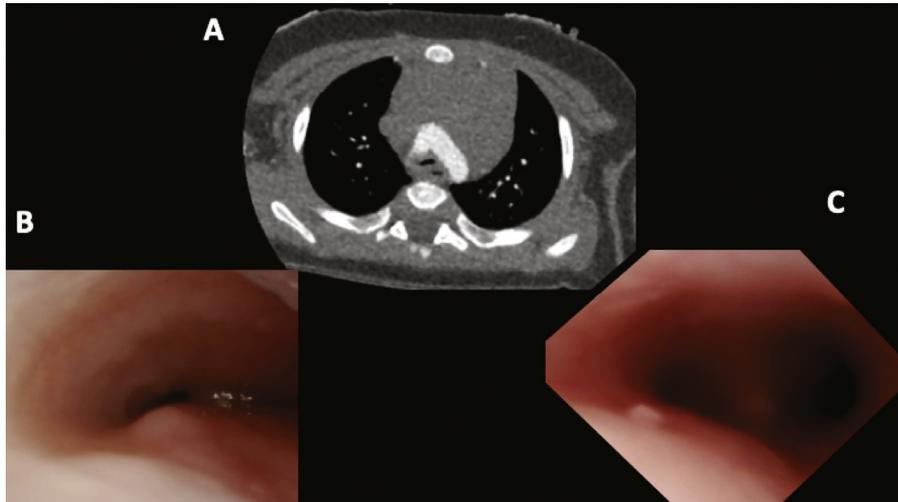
(A) Computed tomography of a patient after double-aortic-arch repair via left thoracotomy with residual airway compression resulting from an aortic stump and a posterior lying aorta. (B) Intraoperative bronchoscopy, with severe tracheal compression before subsequent repair. (C) Intraoperative bronchoscopy after aortic stump resection and anterior aortopexy via median sternotomy.
